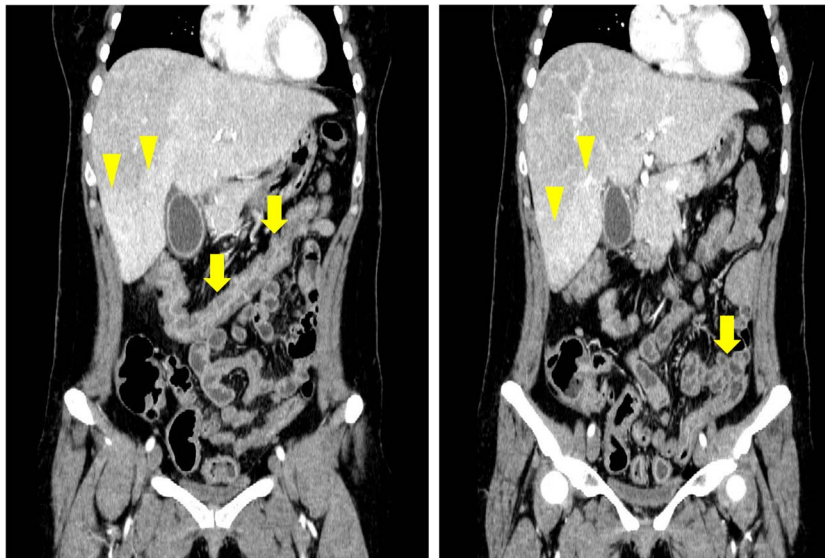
Abdominal contrast CT on admission demonstrated edematous change of the gallbladder, early patchy enhancement of the liver (arrowheads), and edematous change of the intestinal tract (arrows).
